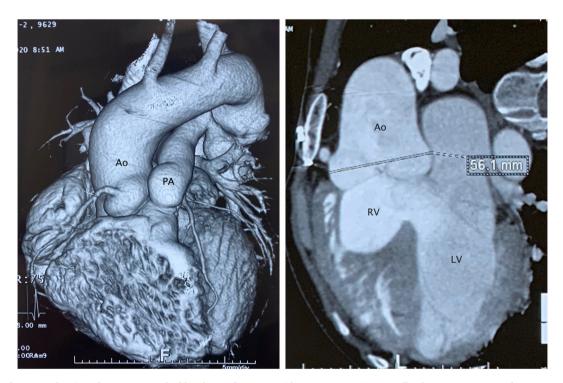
Computed tomography view, showing massively dilated ascending aorta with 56 mm aortic sinus. Small pulmonary artery was also presented. Ao, aorta; LV, left ventricle; PA, pulmonary artery; RV, right ventricle.
